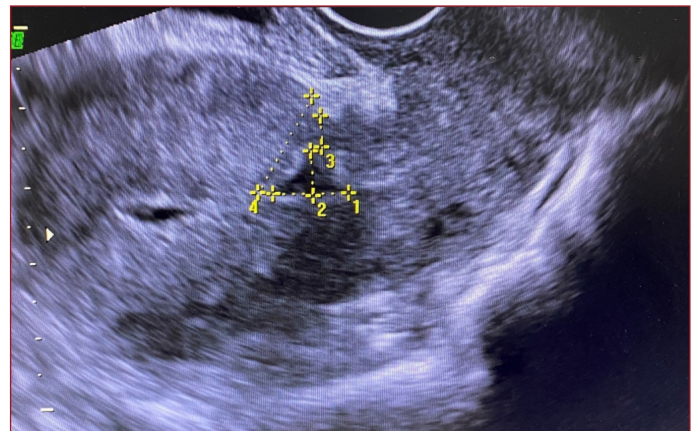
Transvaginal ultrasonographic view of the woman with isthmocele.
